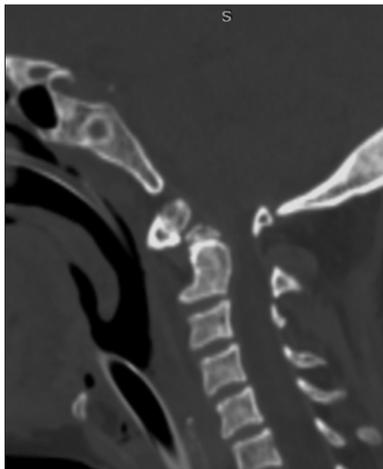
Preoperative sagittal CT scan showing the C2 vertebral body fracture II C.
